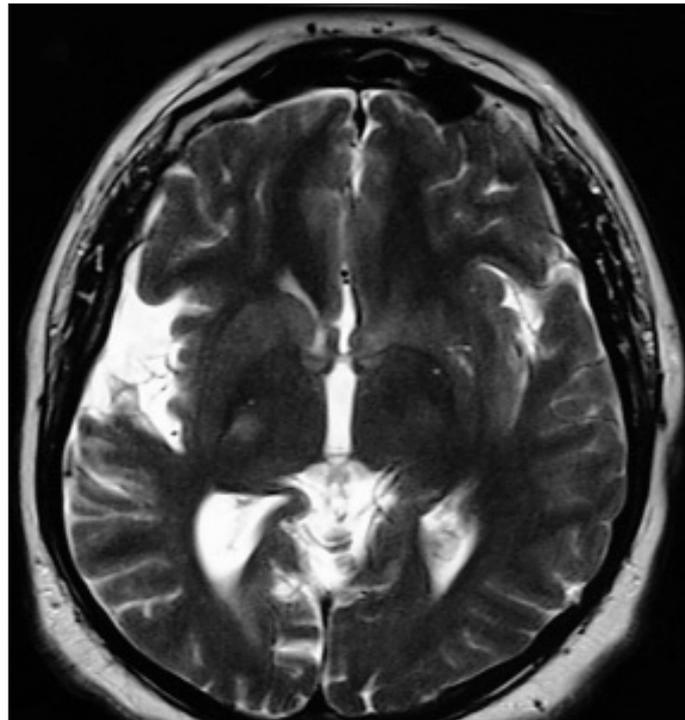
Transverse T2-weighted image showing peripheral sulcal dilation (according to cortical atrophy in the temporo-fronto-parietal lobes of the right cerebral hemisphere).
